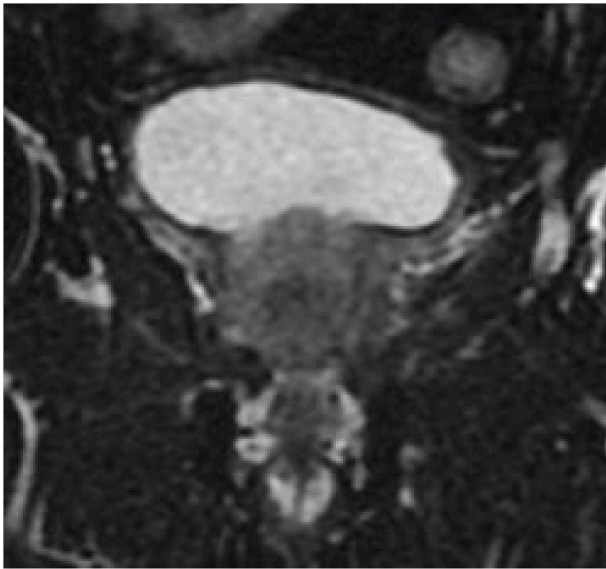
MRI scan shows prostate hyperplasia, abnormal enhancement of prostate.
